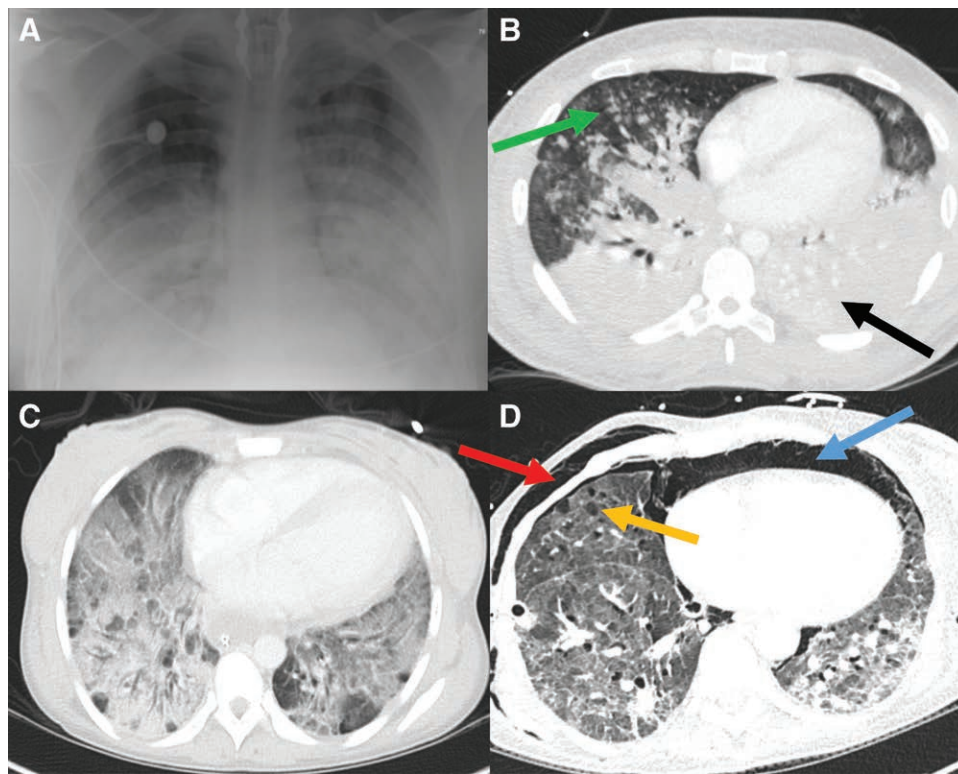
Chest imaging in patients with acute respiratory distress syndrome (ARDS). (A) Plain chest radiograph demonstrates symmetric widespread hazy infiltrates. (B) In the same patient, computed tomography scan confirms the bilateral infiltration observed on plain chest radiograph; however, the infiltrate is predominantly in the dorsal lung (black arrow), and the ventral lung regions are aerated ("baby lung," green arrow). (C) Computed tomography scan showing typical ground glass opacities, indicating severely decreased aeration, but without complete loss of gas content. (D) Computed tomography scan of a patient 16 days after the onset of ARDS, showing diffuse interstitial thickening predominantly at the lung bases, suggesting evolving fibrosis; in addition, ventral bullae (yellow arrow), pneumomediastinum (blue arrow), and soft tissue emphysema (red arrow) represent barotrauma from mechanical ventilation.
